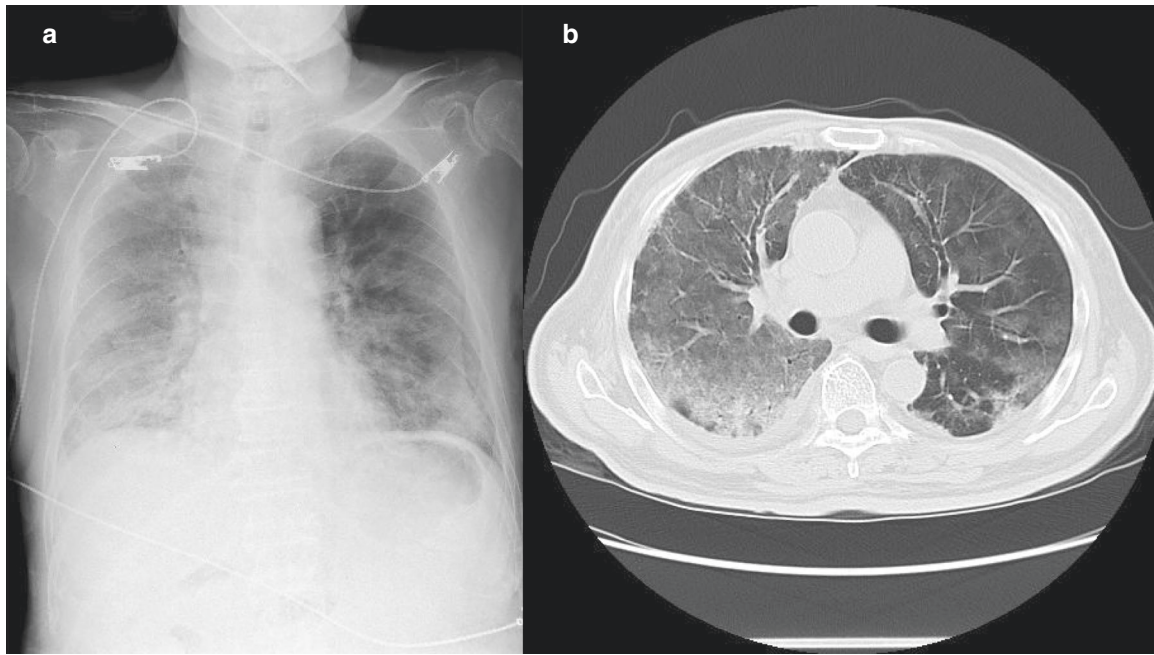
Chest radiography (a) and computed tomography (b) on admission.
